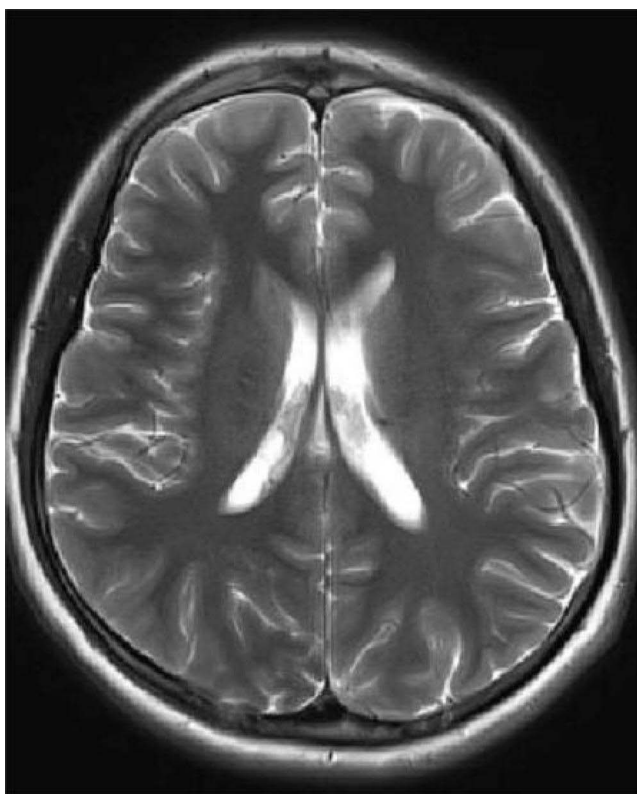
Cranial MRI of the patient in the third month after surgery: bilateral frontal epidural effusions were not shown, original frontal scalp soft tissue swelling was not shown, and the patient recovered well.
